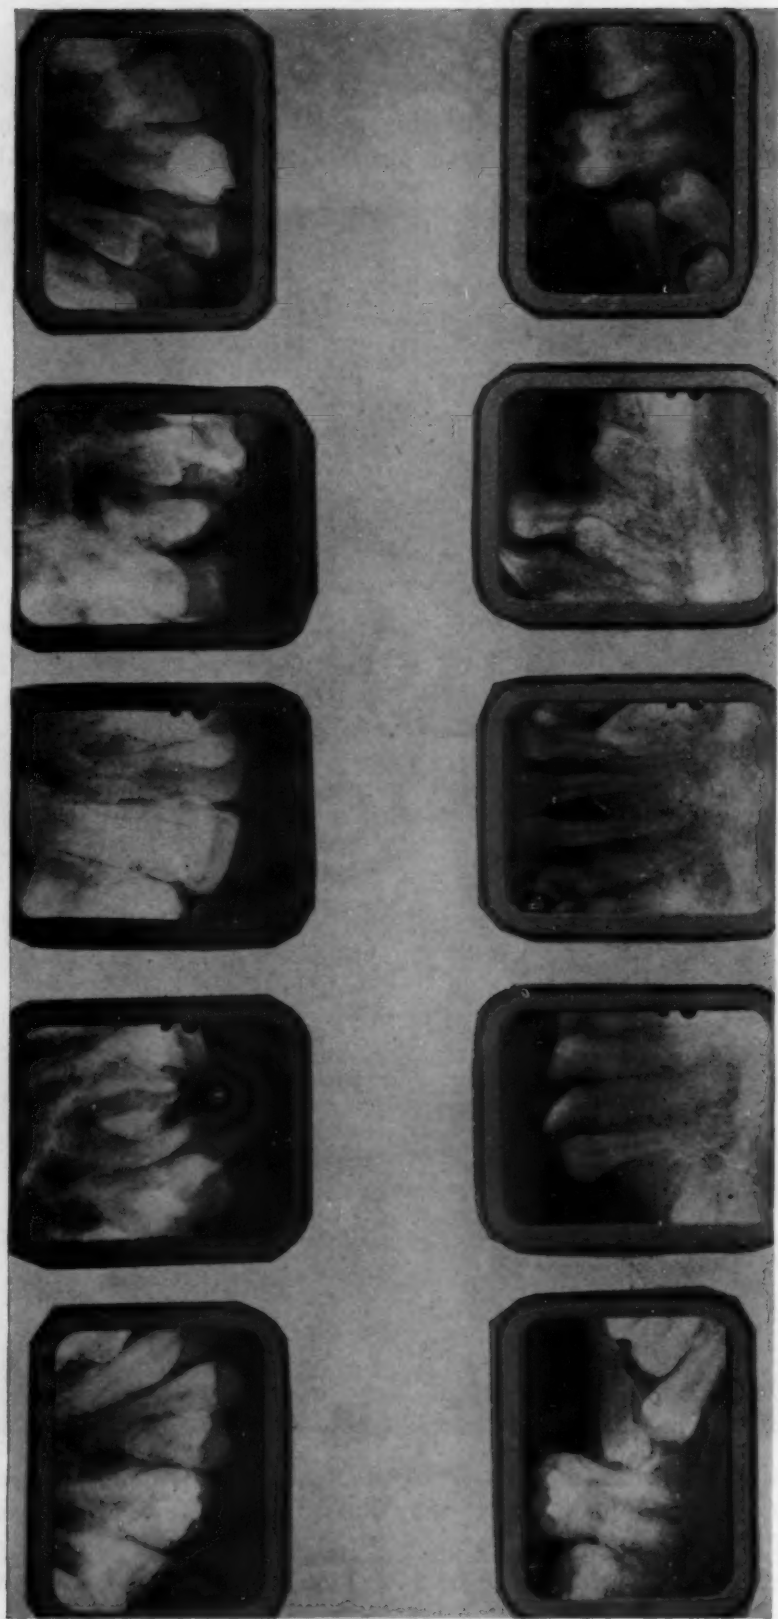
Intraoral x-rays showing impacted and supernumerary teeth. Slb. II-3.
